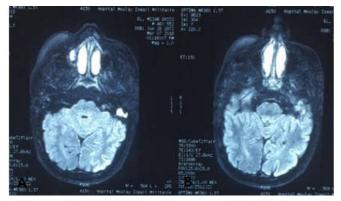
A+B : the T2- weighted MRI revealing a high signal intensity mass the left middle ear cavity without intracranial extension
